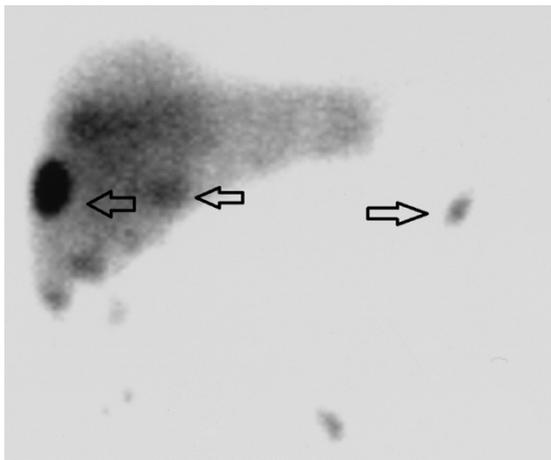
Tc-99m heat damaged erythrocytes scintigraphy, Multiple lesions of uptake in the hepatic parenchyma and left upper quadrant are seen (arrows)
